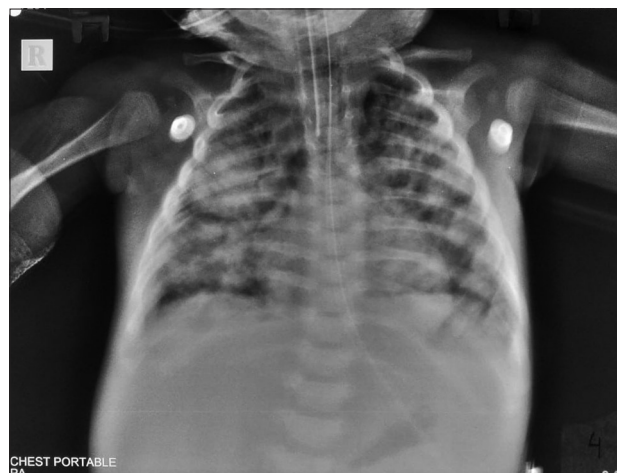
Postintubation chest X-ray, further worsening
